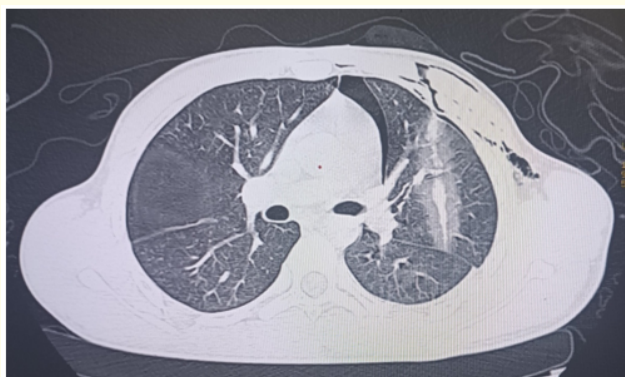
CT scan chest showing linear lung injury and resolving pneumothorax.
